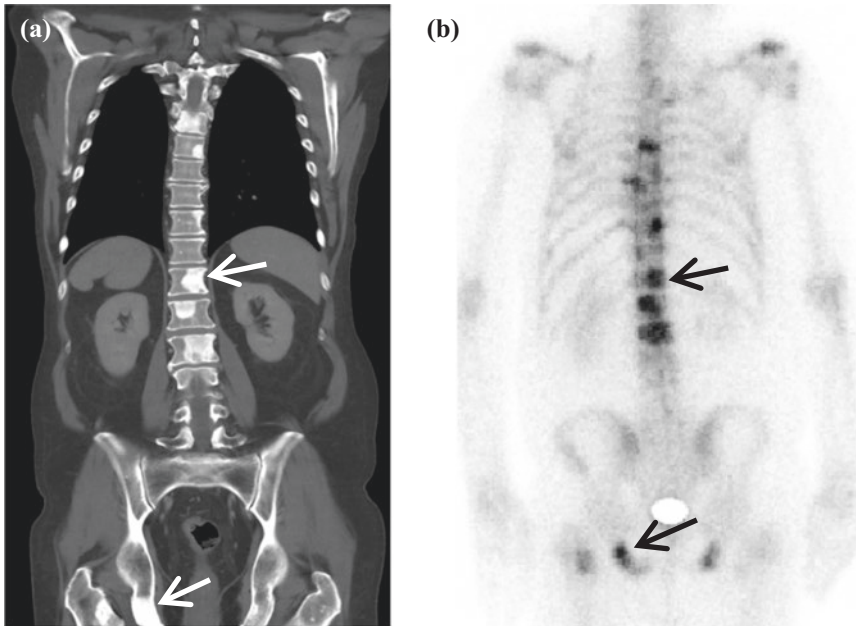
The patient from Fig. 4 had TRUS biopsy of prostate and was found to have Gleason 9 Prostate cancer. He was referred for staging CT and Bone Scintigraphy. a Coronal CT in bone windows demonstrates multiple sclerotic lesions in thoracolumbar vertebrae and pelvis (White arrows). b Bone scintigraphy in same patient shows increased uptake in the same regions (Black Arrows), corresponding to osteoblastic action of prostate metastases
